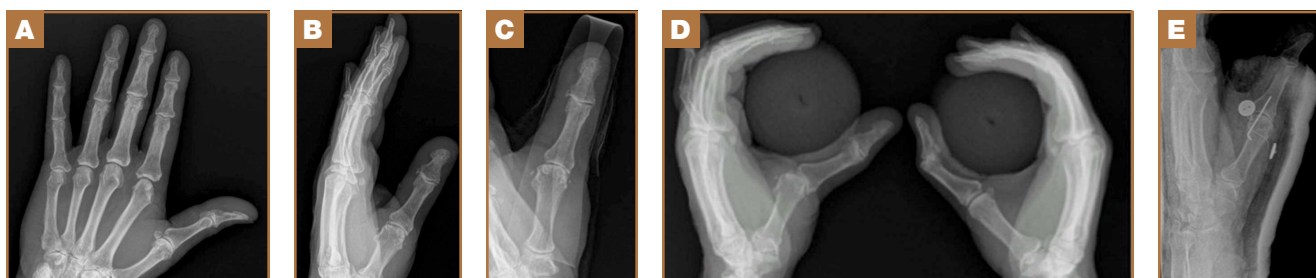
Case 2. A 58-year-old man with left hand injury sustained the previous week. (A) Lateral and (B) posteroanterior radiographic projections of thumb show no bone lesion or ulnar collateral ligament (UCL) lesion. (C) Metal strap as immobilizer; UCL lesion not suspected. (D) UCL lesion with joint tilt of 40°. (E) Surgical treatment with pull-out technique.
